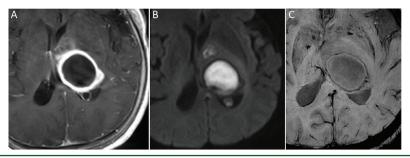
Pyogenic brain abscess due to Streptococcus. There is smooth rim enhancement on postcontrast T1-weighted image (A). Diffusion weighted image (B) shows homogeneous hyperintense signal in central cavity. On the axial SWI (C), the abscess shows the "dual-rim sign".
